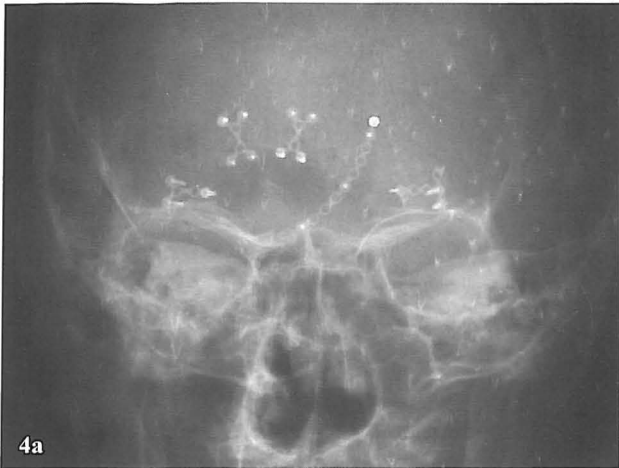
Postoperative skull radiography, AP (a) and lateral (b).
